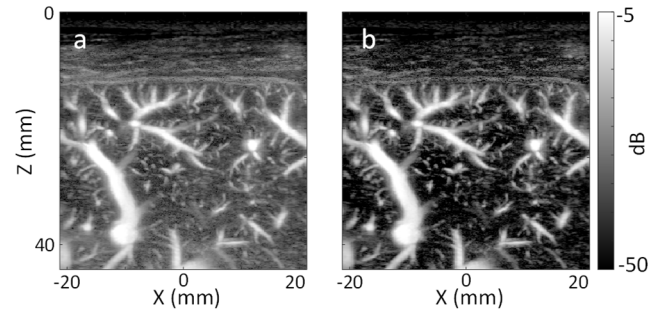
(a) Ultrasound vascular imaging of the liver by the method presented in [20], and (b) the combination of this method with the similarity-based method presented in this study to further enhance the image contrast.
